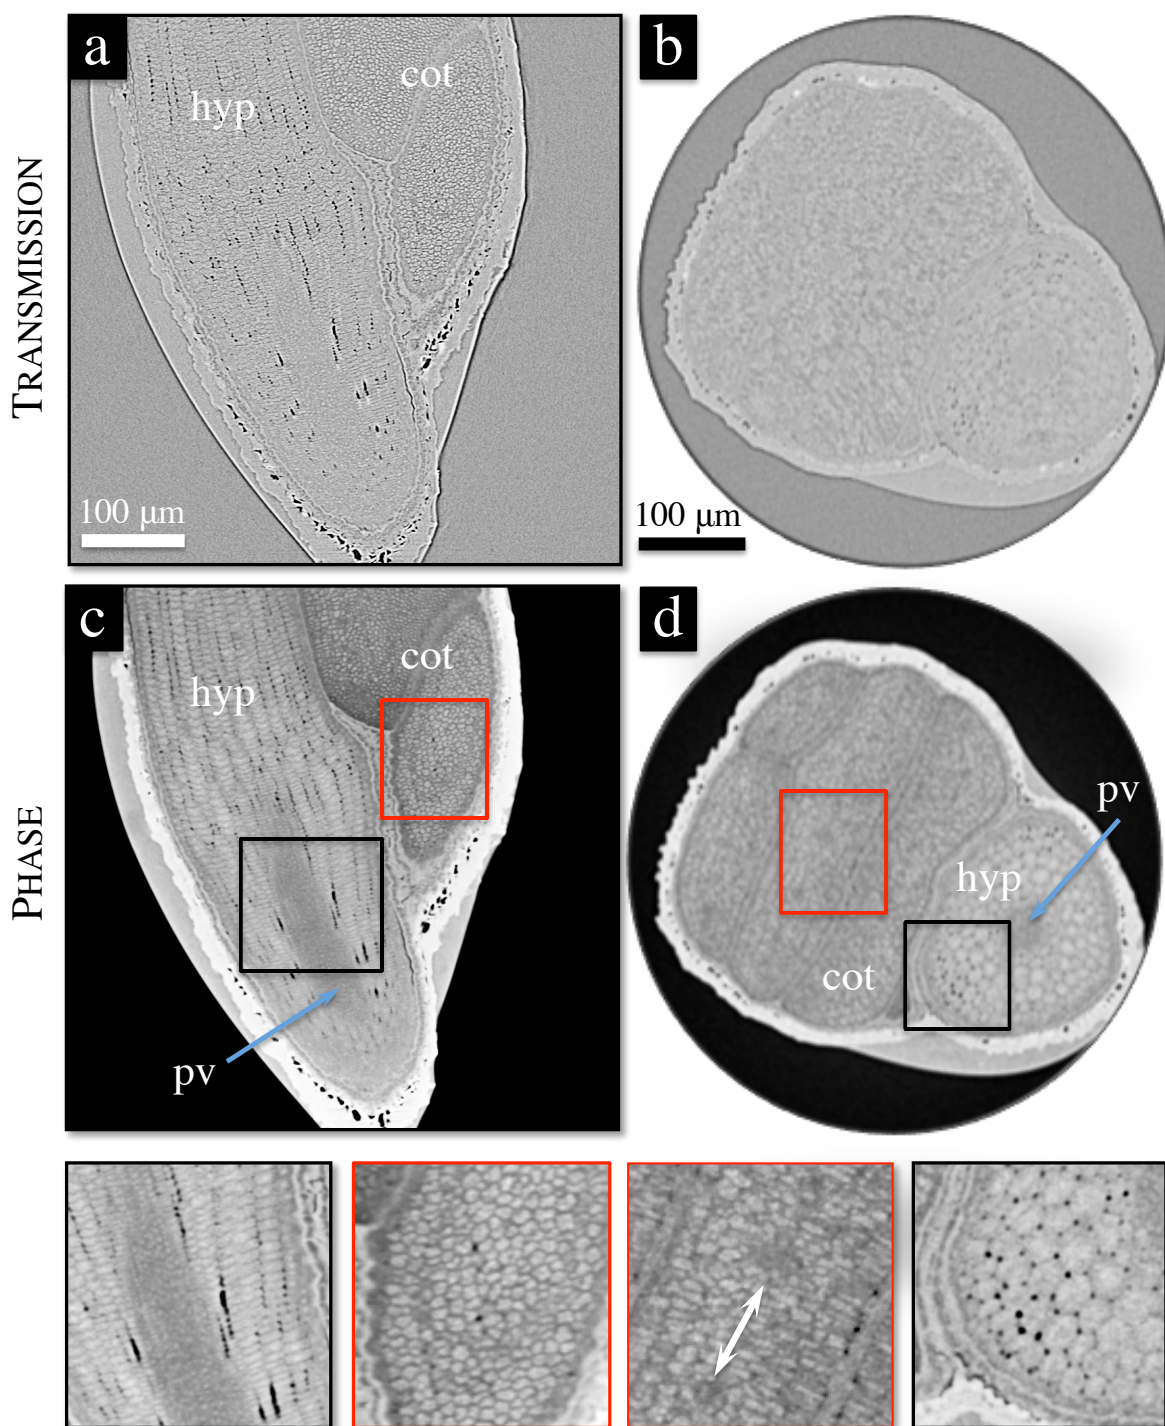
2D slices across a lepidium seed assessed by μ CT. (a) Sagittal and (b) axial slices of the reconstructed μ CT data. (c) and (d) correspond to the reconstruction of (a) and (b) using the single material algorithm. Colored frames are zoomed to the row below. All-important units are abbreviated as follows: hyp, hypocotyl, cot, cotyledon, pv, provasculture. The zoom in the red frame of (d) indicates grey areas, which will be later demonstrated as vascularization.
